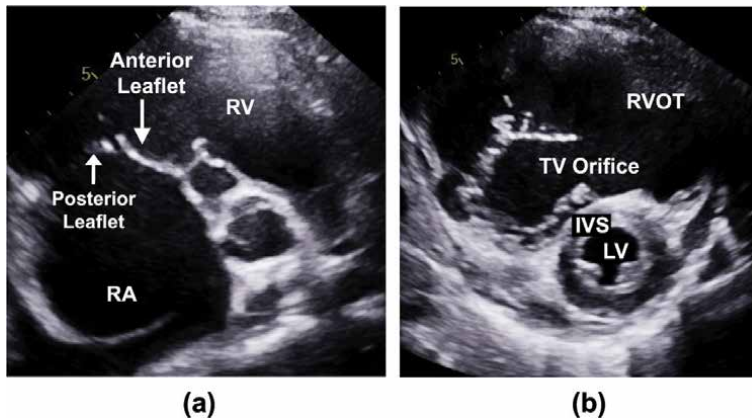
Muscularization and abnormal attachments of the posterior/inferior leaflet of the tricuspid valve by 2D echocardiography and 3D echocardiography showing the muscular “linear” attachments.
